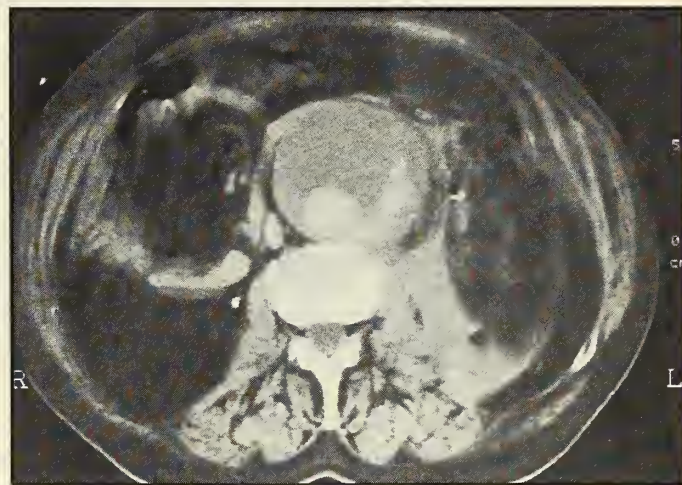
CT scan of the mid abdomen.
